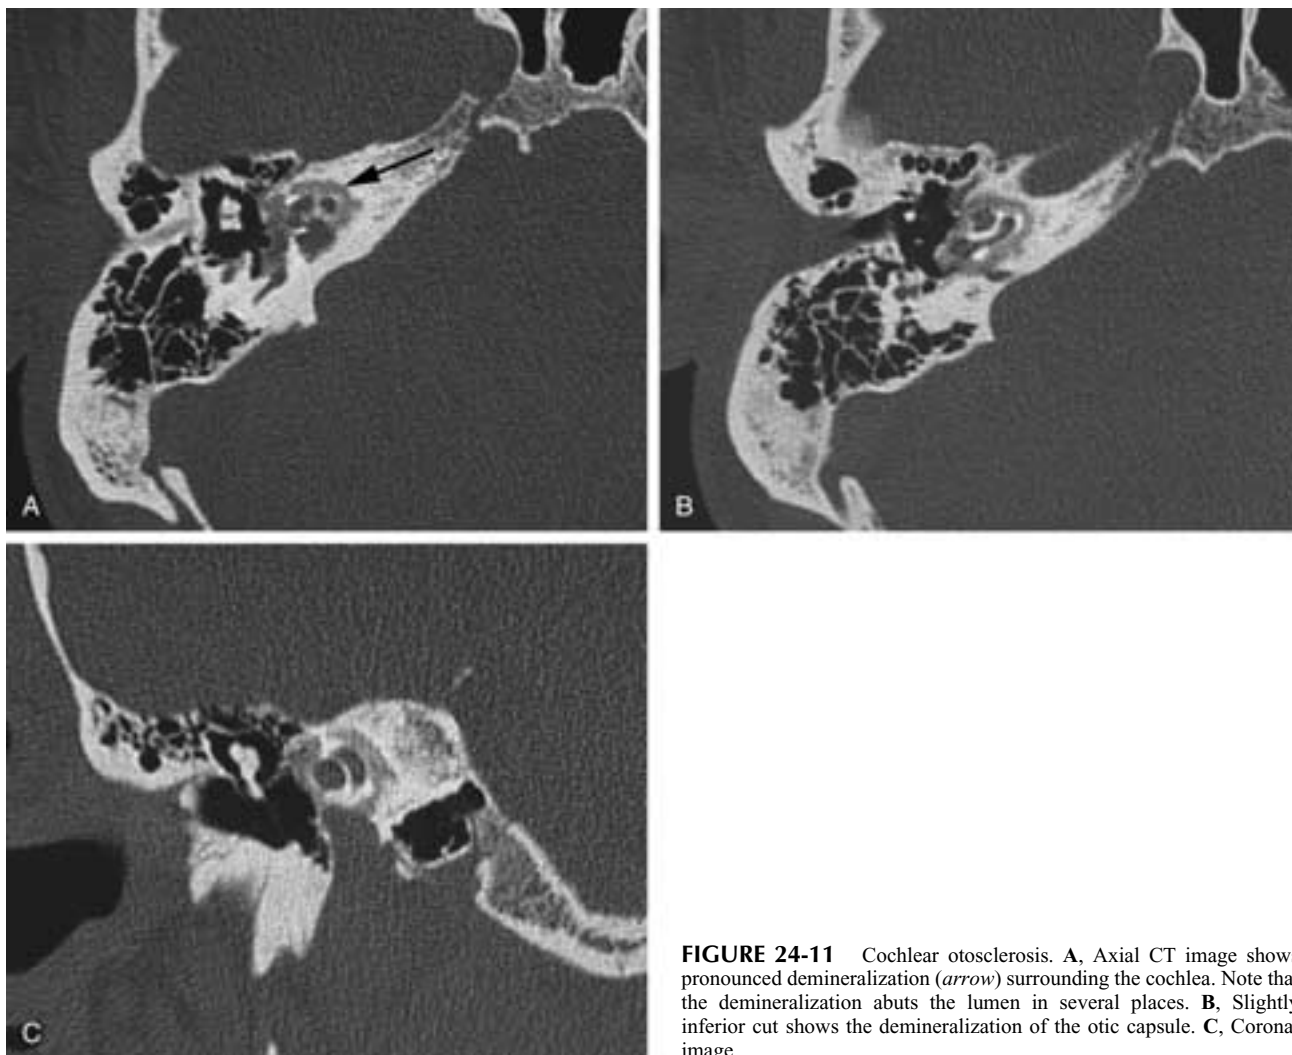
Cochlear otosclerosis. A, Axial CT image shows pronounced demineralization (*arrow*) surrounding the cochlea. Note that the demineralization abuts the lumen in several places. B, Slightly inferior cut shows the demineralization of the otic capsule. C, Coronal image.
